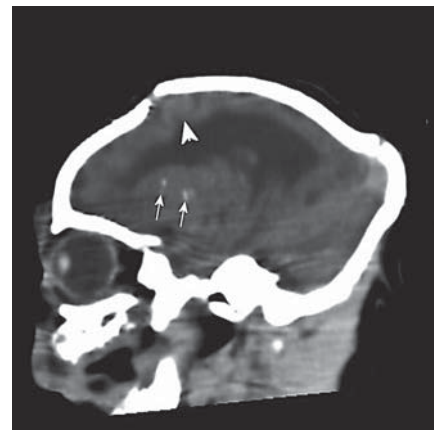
Postnatal CT at day 2. The size of the lateral ventricles remains unchanged. Calcifications are clearly observed (arrows). Note the characteristic skull shape found in patients with congenital Zika virus syndrome as well as in other conditions associated with microcephaly due to severe brain insults (arrowhead).
